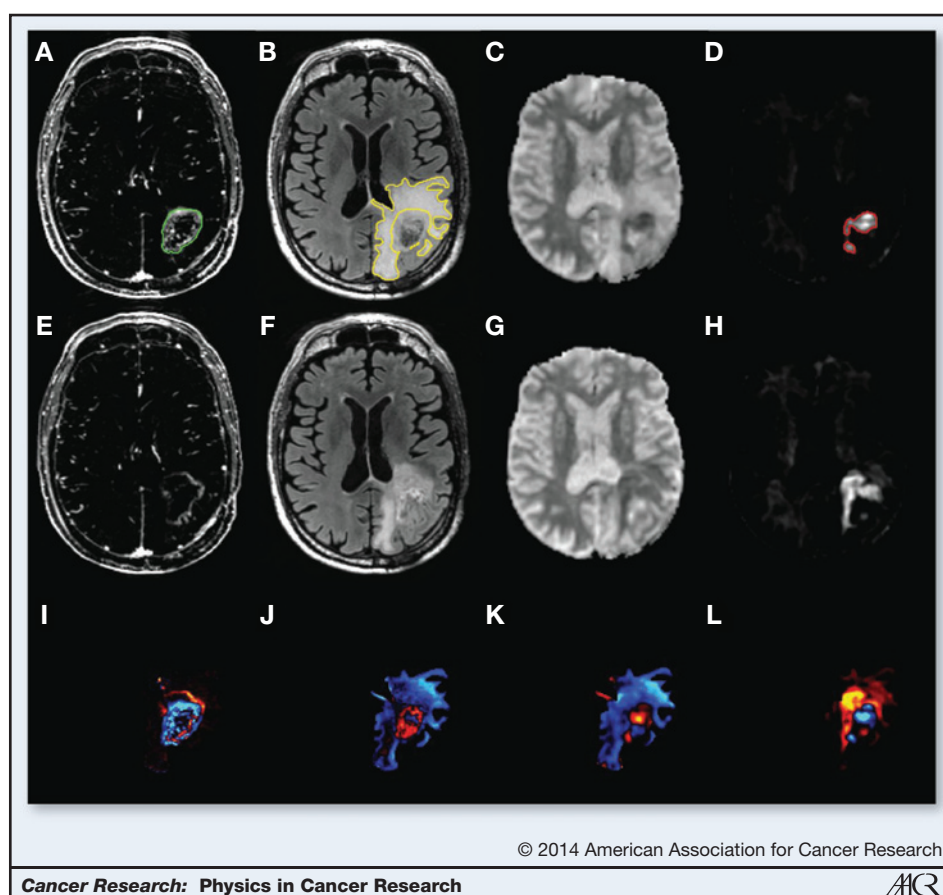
A 67 year old male with left parietal GBM status postresection and chemoradiation. Top, the T_1 postcontrast – T_1 precontrast (A), FLAIR (B), ADC (C), and RSI-CMs (D) before the start of bevacizumab; middle, T_1 postcontrast – T_1 precontrast (E), FLAIR (F), ADC (G), and RSI-CMs (H) after initiation of bevacizumab. Arrowheads, contrast-enhancing region (green), the surrounding region of FLAIR hyperintensity (yellow), and the region of restricted diffusion on RSI-CMs (red). Although there is a decrease in contrast enhancement and surrounding FLAIR hyperintensity after initiation of bevacizumab, the region of restricted diffusion increases and becomes more confluent, suggesting worsening residual/recurrent tumor. Moreover, this increase in the region of restricted diffusion is much more conspicuous on the RSI-CMs compared with the ADC. Bottom row depicts these changes on "change maps" (change in T_1 postcontrast – precontrast; I), change in FLAIR (J), change in ADC (K), and change in the RSI-CMs (L), with red–yellow indicating an increase in signal intensity and blue–cyan indicating a decrease in signal intensity. Of note, on the ADC change map (K), the area of increased restricted diffusion is essentially masked by the decreased signal intensity within the region of surrounding FLAIR hyperintensity.
